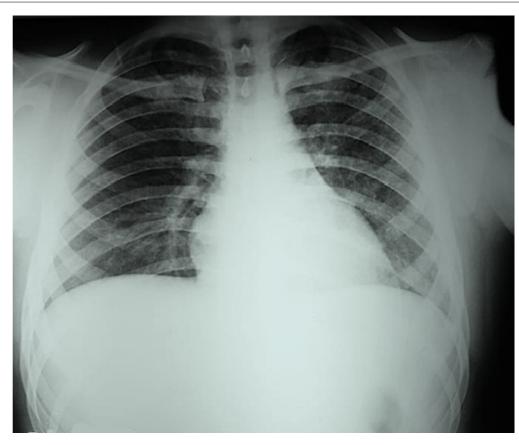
Chest X-ray on admission: bilateral alveolar opacities predominate in the lower left lung field.
